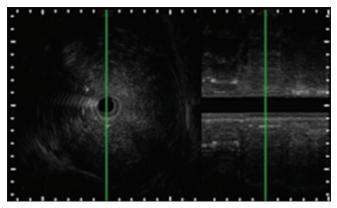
High-frequency endoscopic ultrasound: Marked thickening of the wall of the esophagus with loss of wall stratification
